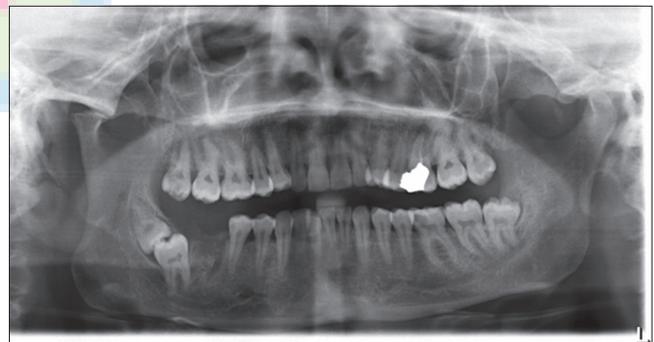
Orthopantomogram revealing impacted lower second and third molars with their crowns facing each other in single follicular space
